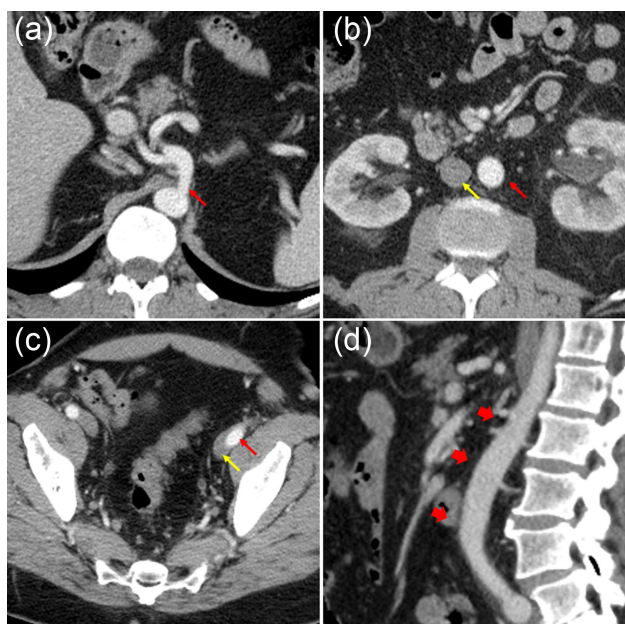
Contrast-enhanced computed tomography of the abdomen and pelvis (A-D) was performed 3 months later in the emergency department for suspected pyelonephritis. Axial image at the level of the diaphragm (A) shows a normal caliber of the origin of the celiac trunk (red arrow). Axial images at the level of the infra-renal aorta (B) and through the mid-pelvis (C) show the normal caliber of the aorta (red arrow in "b") and IVC (blue arrow in "b") as well as left external iliac artery (red arrow in "c") and external iliac vein (blue arrow in "c"). Sagittal MPR image (D) demonstrates the normal caliber of the abdominal aorta (arrows).
